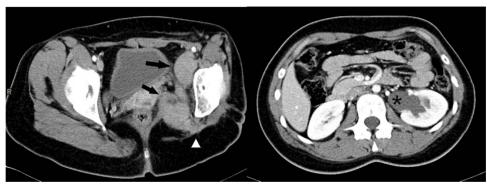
Computed tomography of 2010, axial plane, and contrast-enhanced: the lobulated soft tissue mass (black arrows) along the left pelvic sidewall is increased in size, now encasing the left external iliac vessels, infiltrating the left obturator internus and levator ani muscles, and extending through the sciatic notch (white arrowhead). The mass obstructs the left ureter resulting in moderate hydronephrosis (asterisk).
